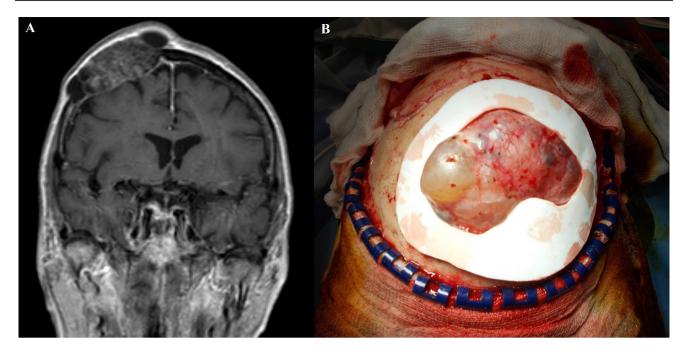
A A coronal MRI showing the presence of destructive lesion involving the calvaria. B Use of a cutting guide to decide the extent of craniectomy
